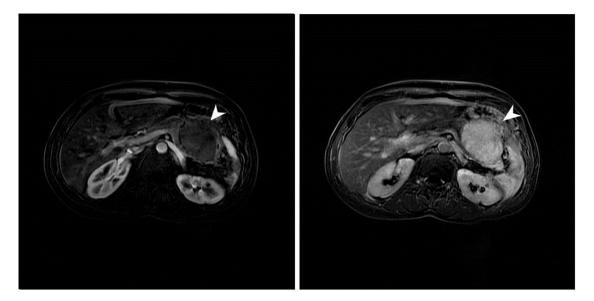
Axial T1-weighted fat-suppressed subtraction magnetic resonance images after contrast administration during the arterial (a) and late (b) phases.
